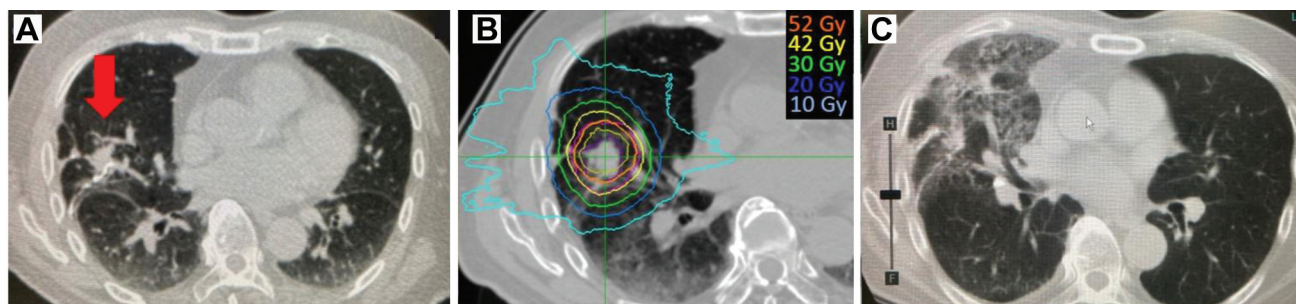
Data of patient with cT1bN0M0 (stage IA) lung cancer with interstitial pneumonia who developed grade 5 radiation pneumonitis and acute exacerbation of interstitial pneumonia. A: Computed tomography images before stereotactic ablative radiotherapy. B: Dose distribution. C: Radiation pneumonitis appears extensive after 3 months; this was followed by exacerbation of interstitial pneumonia, resulting in death.
